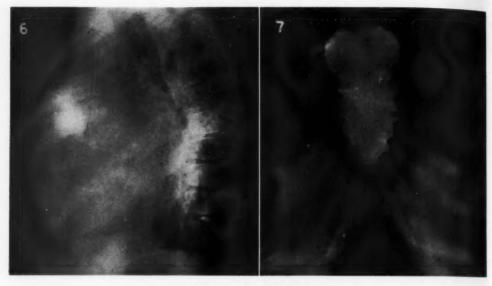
Case II. Lateral roentgenogram of the chest taken at six months of age. The sternum is angulated forward and is entirely devoid of suture lines.
